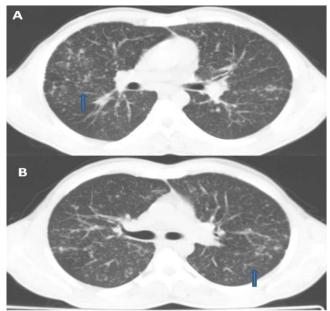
Unenhanced chest CT axial images show numerous, variablesized nodules with a noncalcified, centrilobular distribution typical of DIPNECH cases (blue arrowheads) (a-b)
